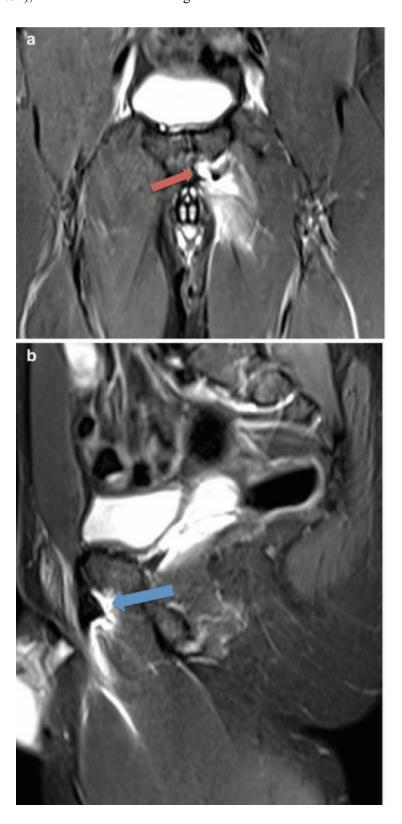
A 31-year-old male athlete with adductor longus (AL) proximal tendon avulsion and detachment of the rectus abdominis-adductor longus (RA-AL) aponeurosis. (a) Coronal and (b) sagittal short tau inversion recovery MRI show avulsion of the proximal tendon of the left AL with an osseous defect at the left pubic tubercle (*red arrow*). Sagittal image shows tenoperiosteal detachment of RA-AL aponeurosis (*blue arrow*)
